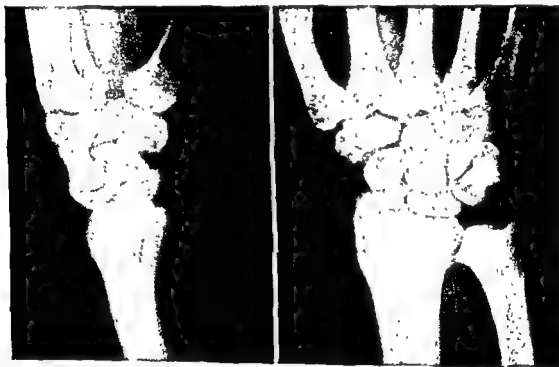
X-ray of perilunar dislocation of the carpus
